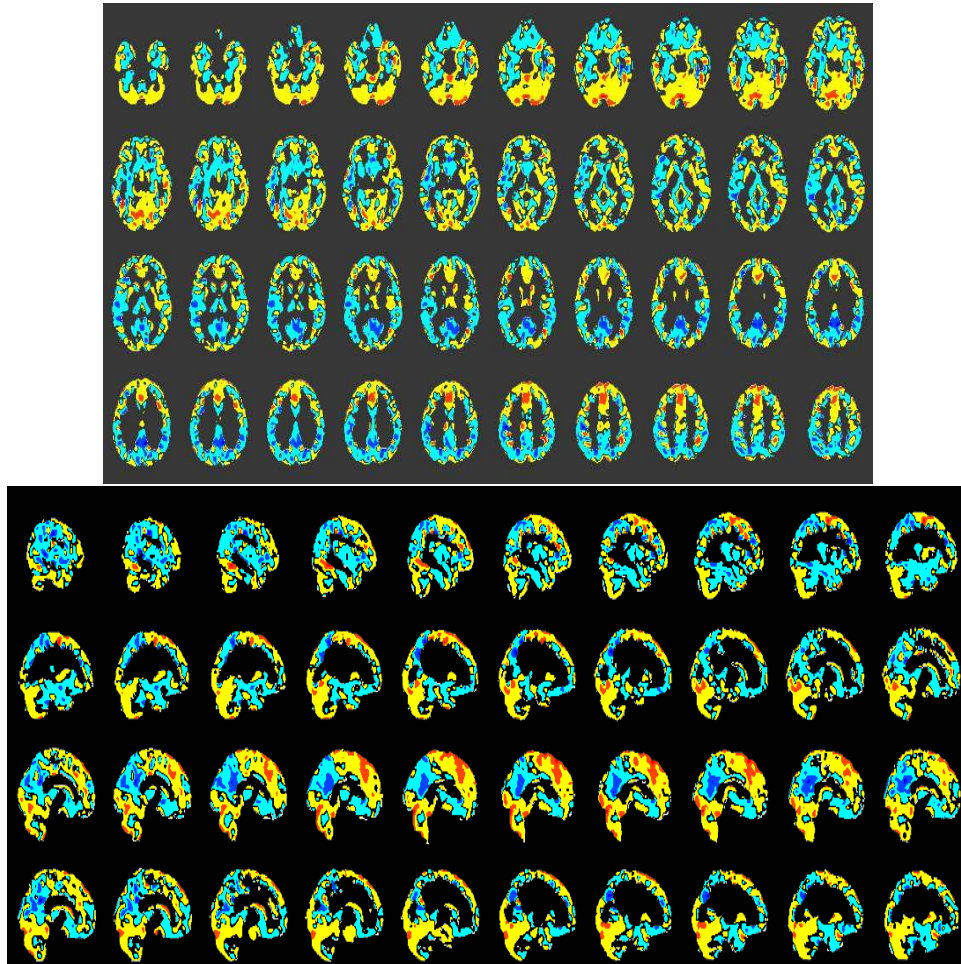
Weighted MRI of grey matter volume influence. The blue and red represent opposite change influence where blue is the negative values and red is the positive values.
